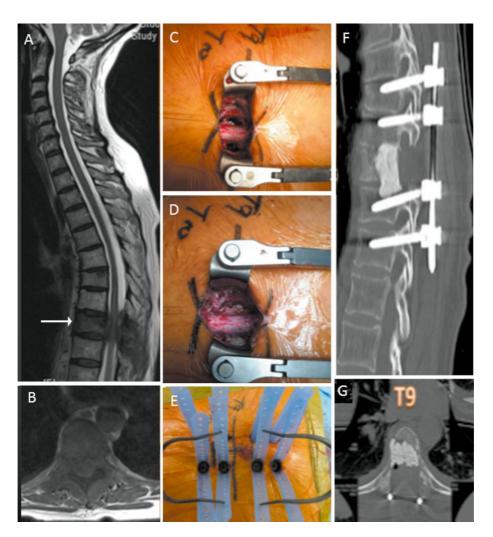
A 58-year-old woman with lung cancer presented with midthoracic pain of 2 months duration. (A) and (B) MRI images showing circumferential spinal cord compression at T₉ level. (C) Intraoperative photograph showing mini-open midline linear incision with bilateral pediculectomy and vertebrectomy. (D) Post vertebroplasty with cement augmentation. (E) Intraoperative photograph showing percutaneous sleeves in situ. (F) and (G) Post-operative CT scan images.
